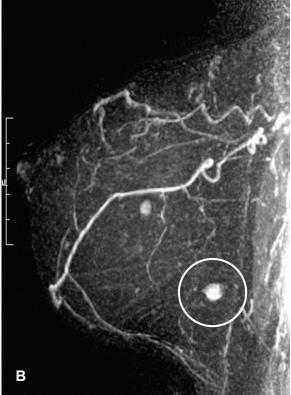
Examples of axillary lymphadenopathy revealed by MRI. (A) Mass behind the nipple. (B) Mass in the inferior breast.
